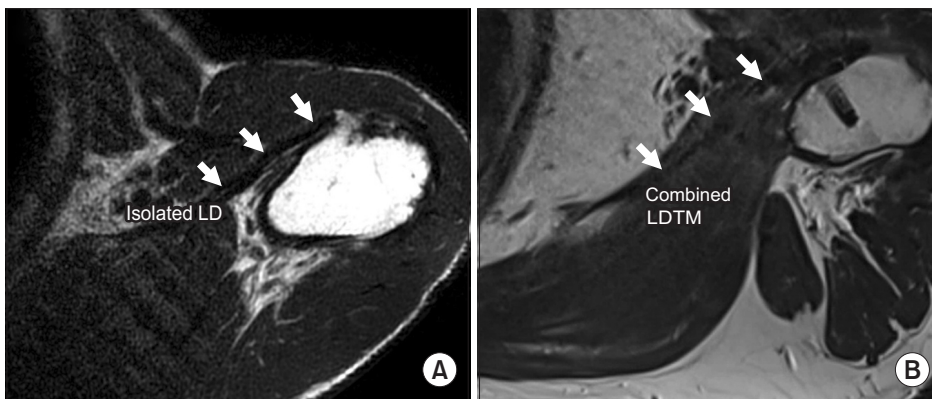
T2-weighted oblique axial-view magnetic resonance imaging demonstrating intact integrity of the transferred latissimus dorsi (LD) (A) and combined latissimus dorsi and teres major (LDTM) tendons (B), indicating difference in thickness of each transferred tendon. Arrow: isolated LD (A), combined LDTM (B).
